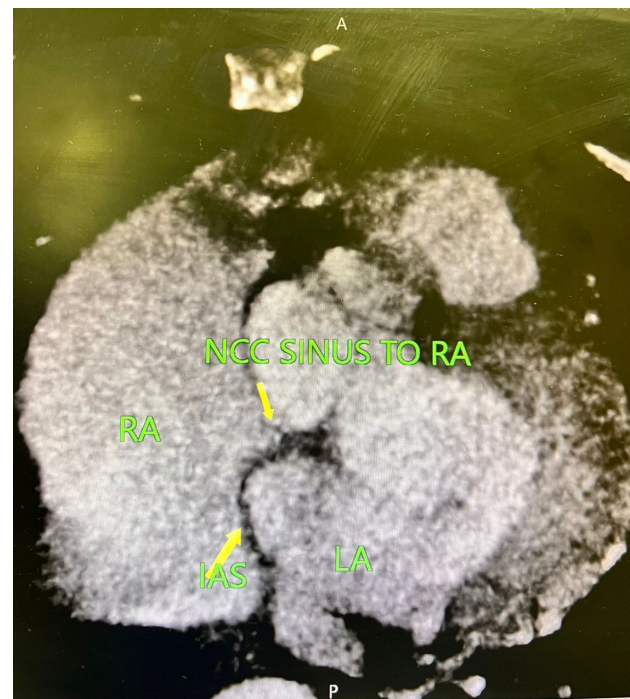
CT angiographic image showing the ruptured sinus of Valsalva aneurysm arising from the non-coronary sinus into the right atrium.
